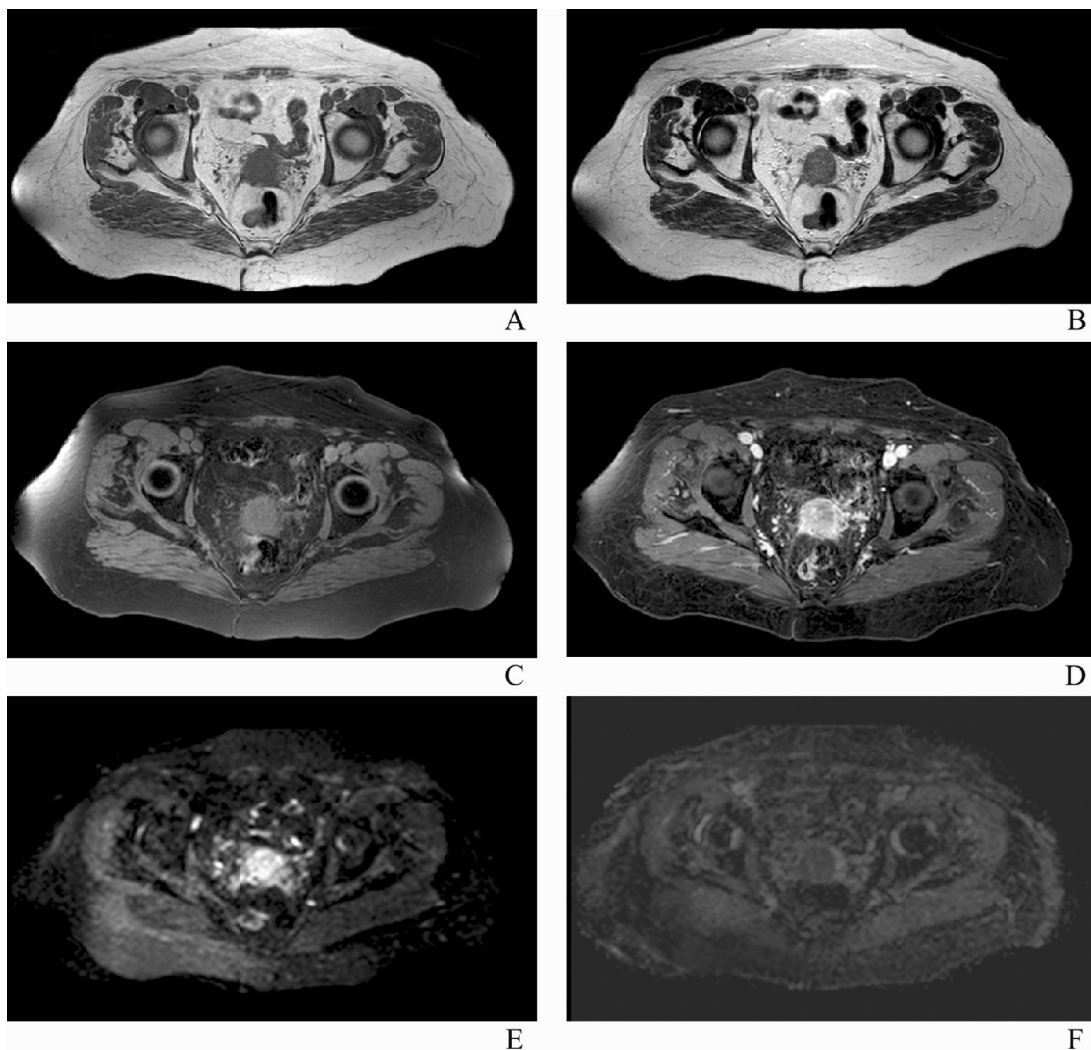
Cervical cancer on axial sections in T1-weighted (A), T2-weighted (B), WAVE and T1-weighted post contrast images (D), DWI (E) and ADC map (F)
